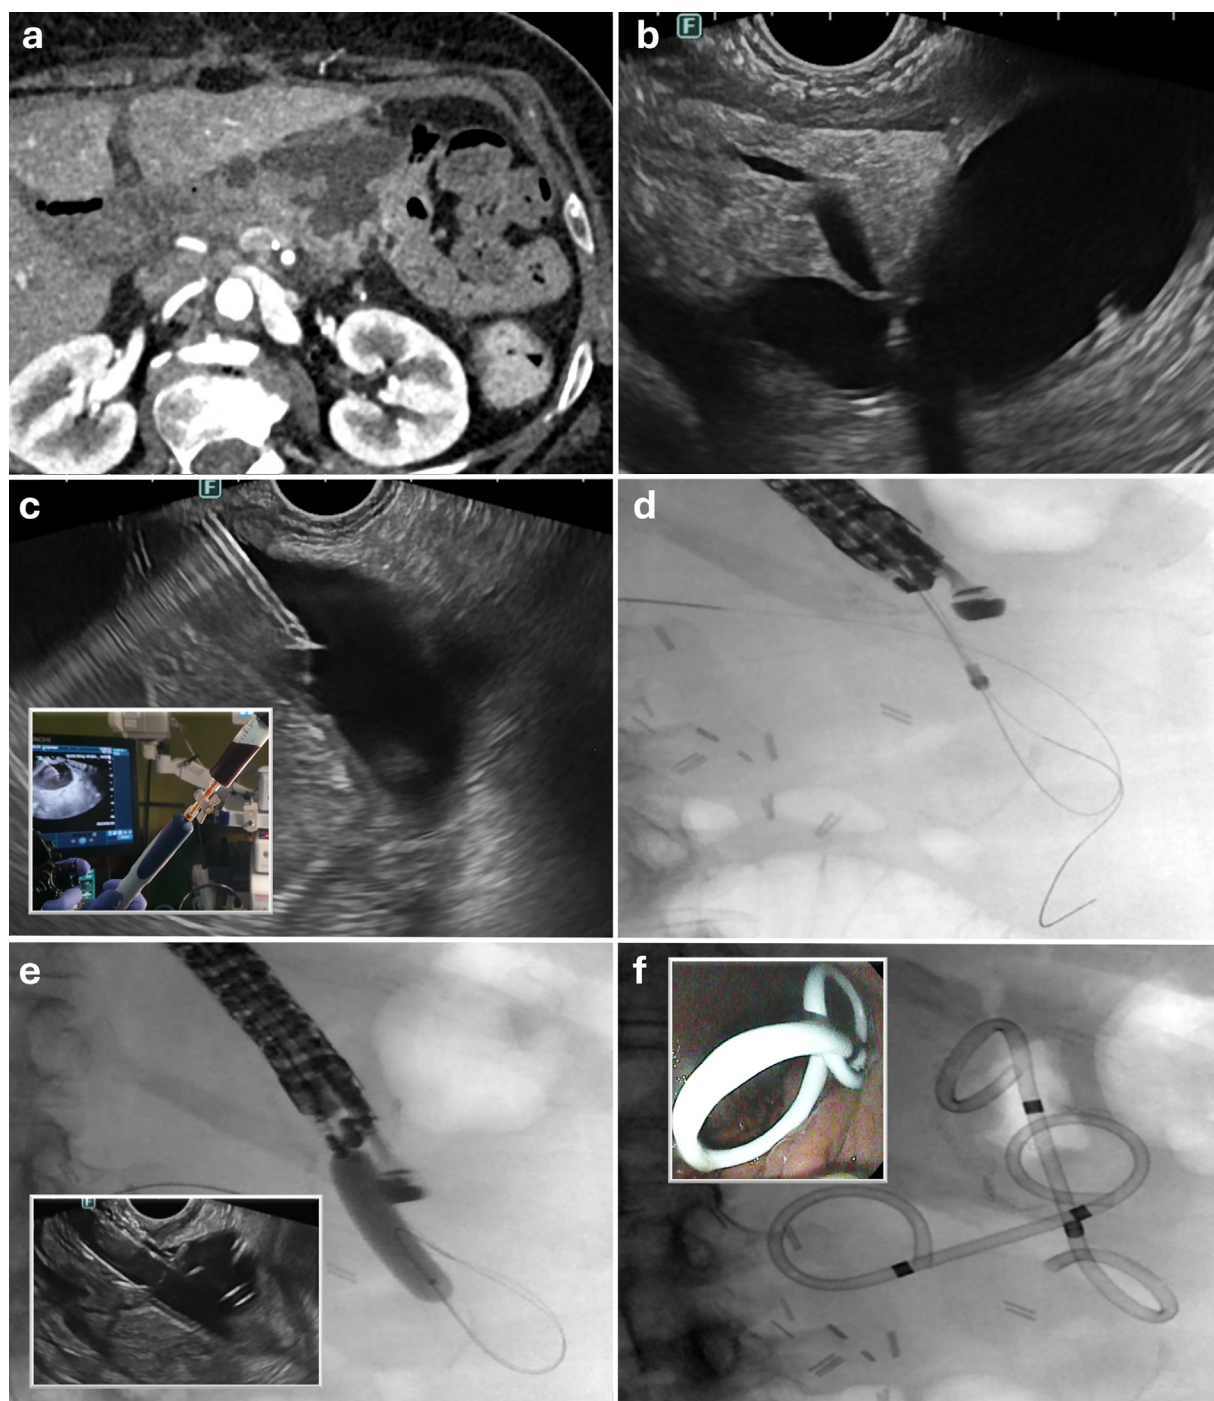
Post-Surgical Collections: a) CT scan of a collection following pancreatoduodenectomy; b) EUS showed a small fluid collection surrounding the pancreatoco-jejunostomy; EUS showed an homogenously fluid appearance, with no necrotic components; c) the collection was punctured with a 19G needle, for microbiological sampling; d) a guidewire was introduced through the needle, thereafter guiding a 10Fr cystotome tract creation; after the cystotome is inside the collection, a second guidewire was advanced; e) tract dilation with a 8 mm balloon; f) placement of two 10Fr double-pigtail plastic stents in the two directions of this bilobar collection.
